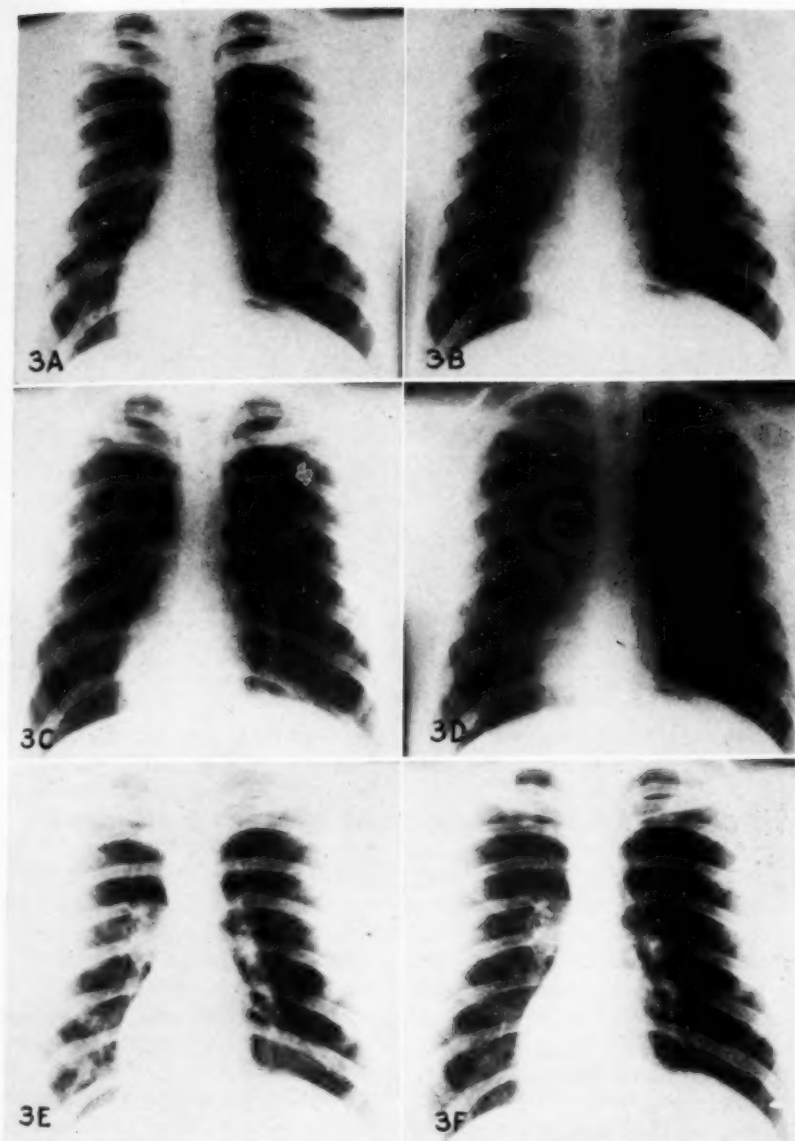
Comparison of low *versus* high kilovoltage roentgenographic techniques as applied to duplitized *versus* single emulsion films, showing results obtainable with and without a grid (i.e., with the higher kilovoltages). The factors were as follows:
